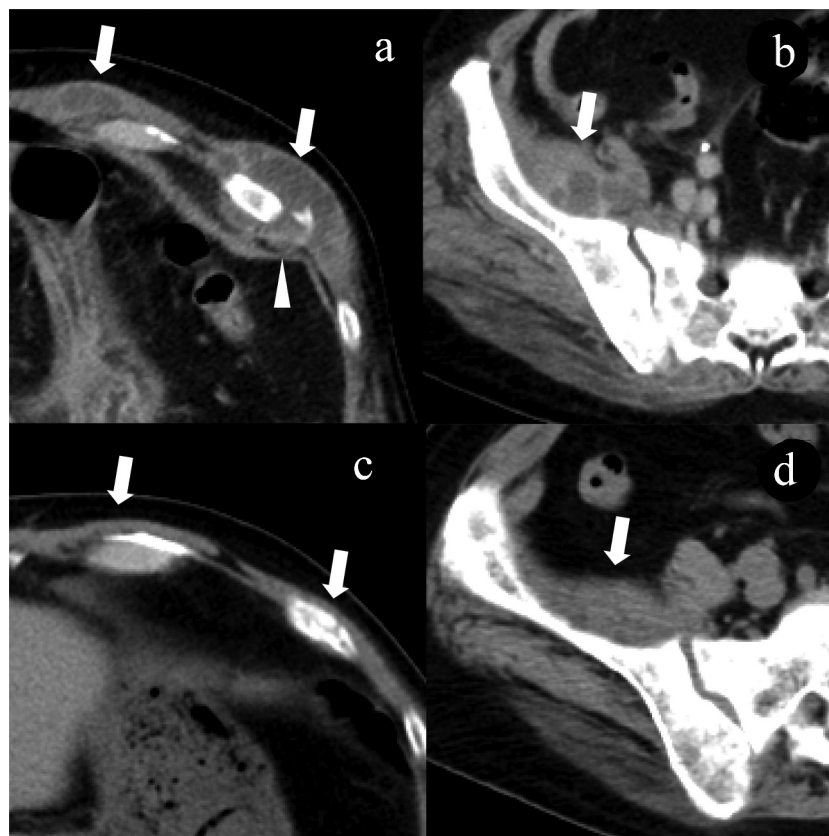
Chest and pelvic computed tomography scans in our patient. Before treatment, there is a left rib fracture (A, arrowhead), and the adjacent muscles (A, arrow) and right iliac muscle (B, arrow) are swollen, with fluid retention. There is resolution of these muscle abscesses after treatment (C and D, arrow).
